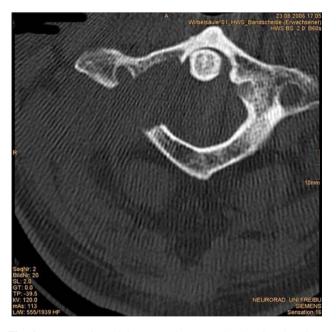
Postoperative axial computed tomography showing that about a third of the posterior arch of C1 was removed
